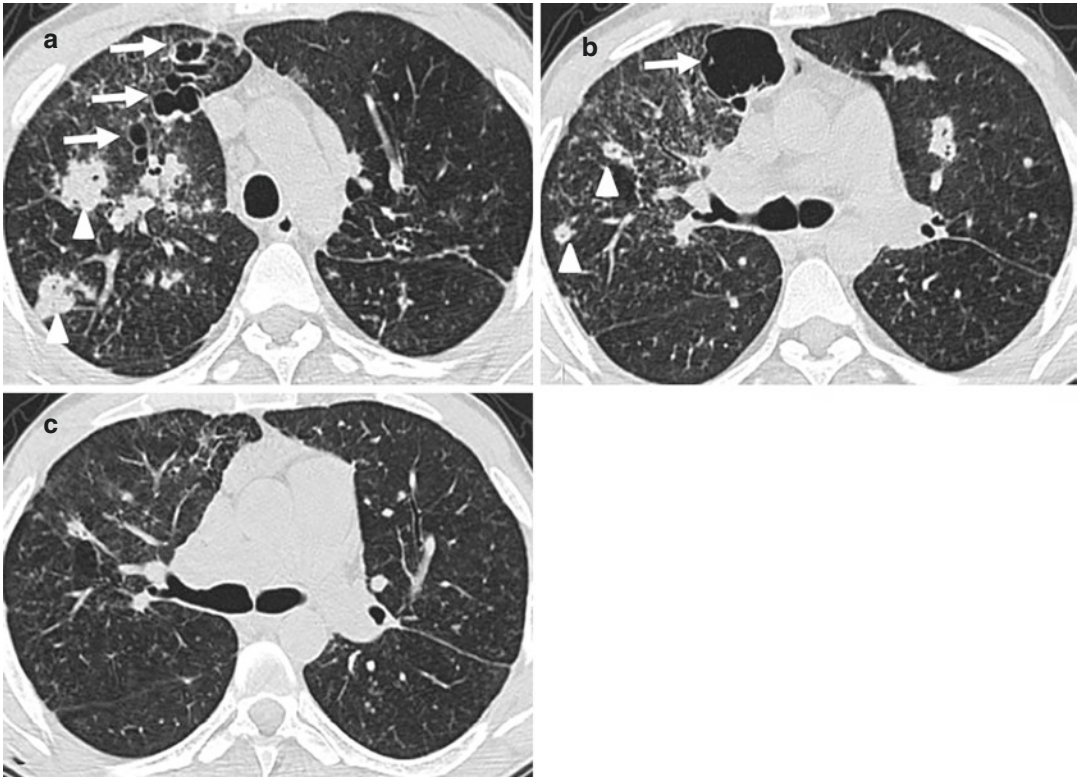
Atypical form of pneumocystosis. (a and b) Axial CT images show right upper lobe cystic lesions (arrows) associated with nodules, most of which are cavitated (arrowheads). (c) Follow-up axial CT image shows clear regression of lesions after treatment
